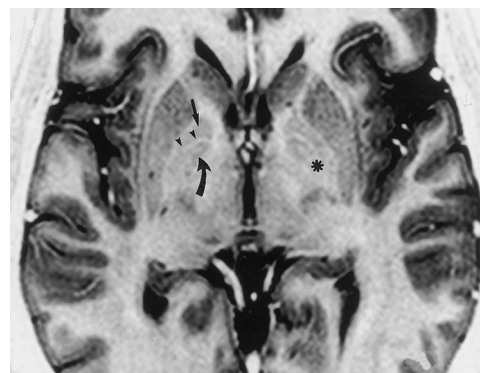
Turbo spin-echo IR (3000/40/4) axial MR image shows the site of the pallidotomy in the posteroventral GPI (asterisk). Globus pallidus interna (curved arrow), globus pallidus externa (straight arrow), and lamina medullaris medialis (arrowheads) are also shown.
